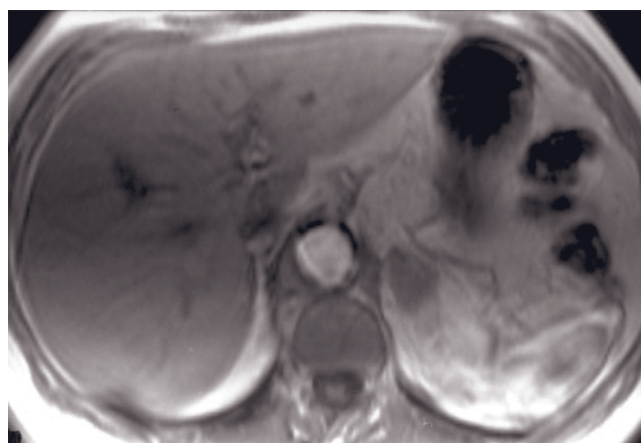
(Continued) and out-of-phase (i) SGE images at 1.5T and T1-weighted in-phase (j) and out-of-phase (k) SGE images at 3.0T demonstrate right adrenal adenoma in the same patient. The adenoma shows signal drop out-of-phase image (i) compared to in-phase image (h) at 1.5T. However, the signal drop on out-of-phase image (k) compared to in-phase image (j) is less than that at 1.5T. The different T1 contrast resolution of 3.0T MR imaging and the inability to use exact in-phase/out-of-phase TE times at 3.0T impair the ability to detect fat content in the lesions at 3.0T in a consistent fashion. This is particularly true for small lesions.
